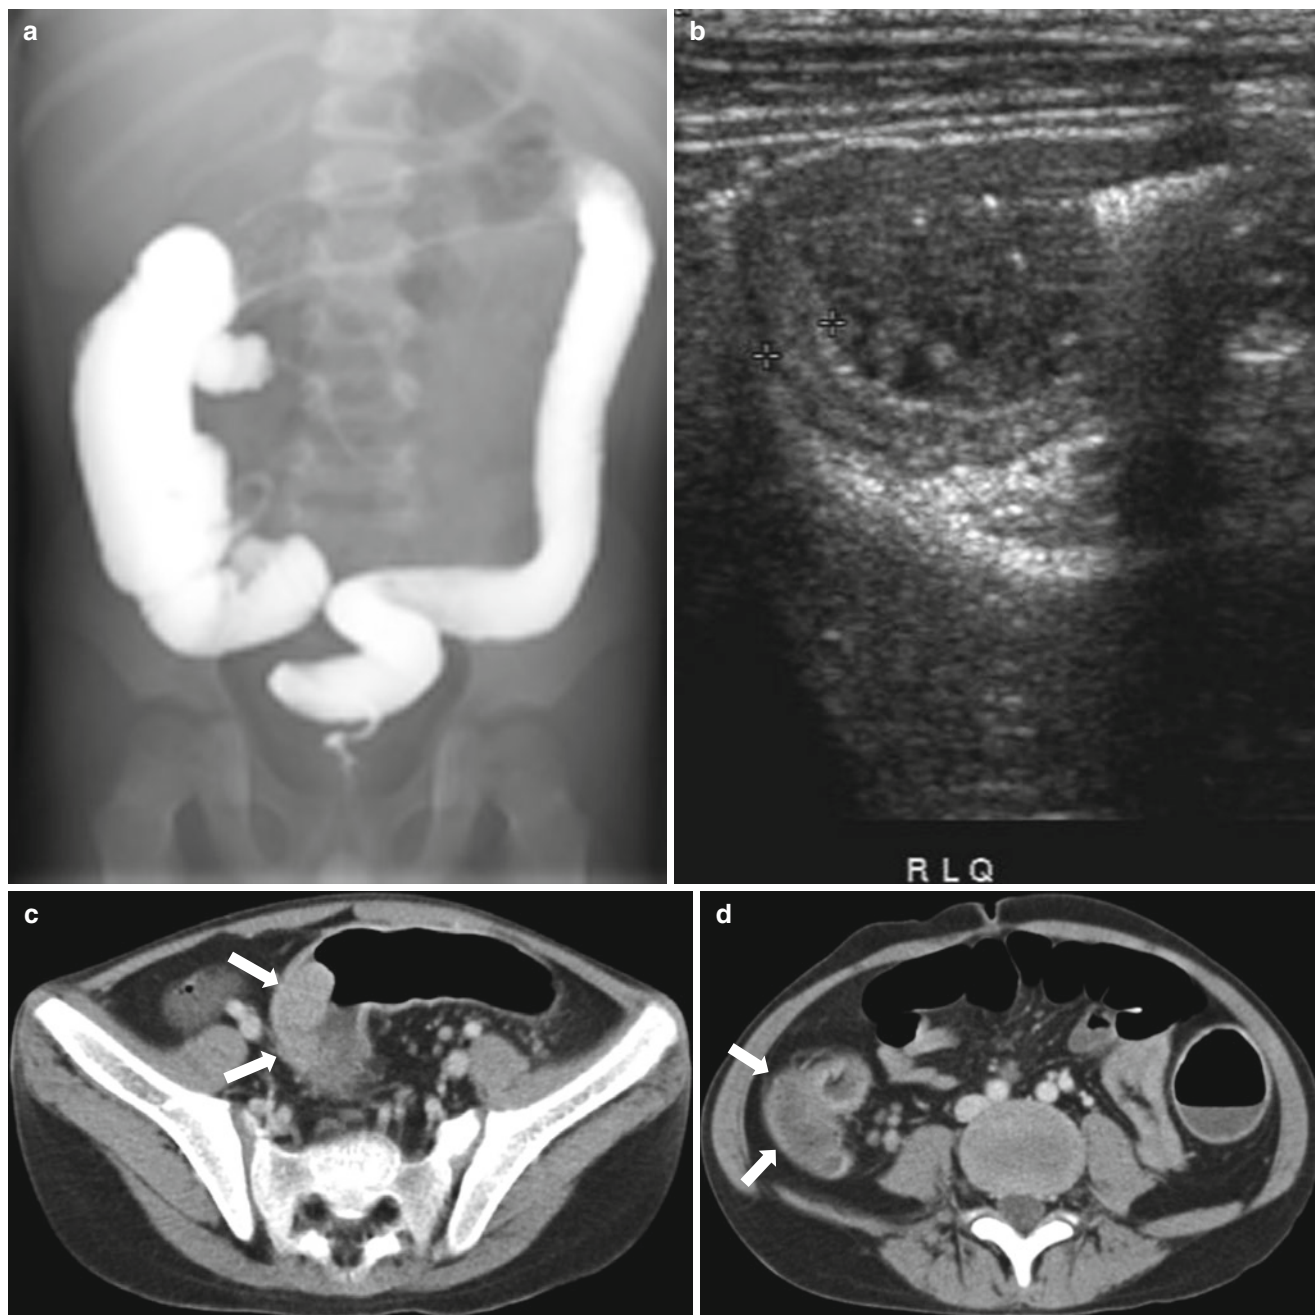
Ulcerative colitis. (a) Barium enema of a 5-year-old boy shows loss of haustra and fine nodularities in the descending colon and transverse colon. (b) Ultrasound demonstrates diffuse bowel wall thickening in the entire colon. (c, d) Follow-up CT obtained 10 years later
